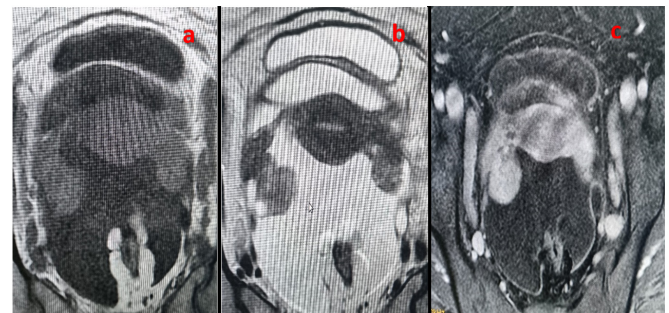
Axial slice in T1(a), T2(b) and T1 weighted sequence after Gado injection (c) of a pelvic MRI showing two bilateral ovarian masses which enhance after injection with abundant peritoneal effusion.
